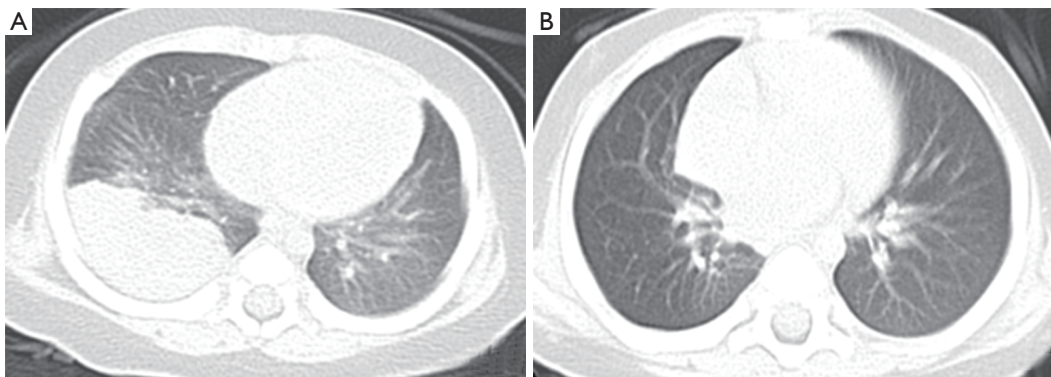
A 85-day-old boy with CPAM in the lower lobe of the right lung, Stocker type 1. CT plain scan images showed that: (A) repeated infection in the lower lobe of the right lung led to lung consolidation; (B) 1 year after resection of the lower lobe of the right lung, there was no residual lesion and inflammation disappeared. CPAM, congenital pulmonary airway malformation; CT, computerized tomography.
